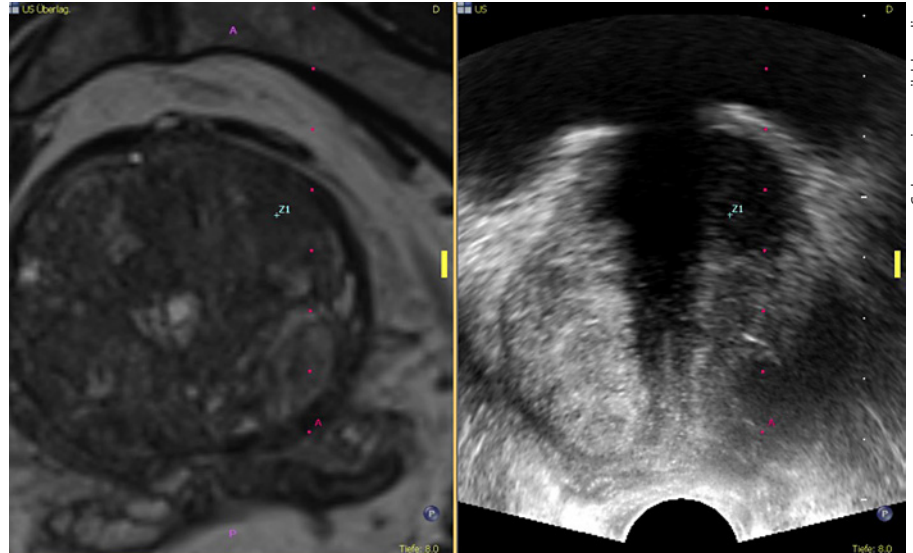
Image fusion of the lesion in side-by-side view showing the lesion in the mpMRI in the anterior part of the prostate (marked with Z1) and the corresponding hypodense lesion in the B-mode ultrasound imaging (marked with Z1). Due to the fusion system, the image is reversed right to left.
